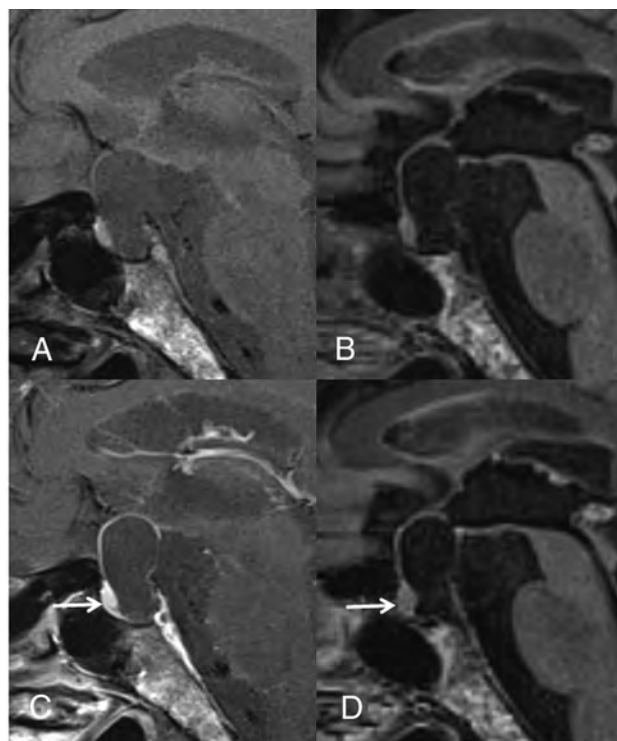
A 60-year-old man with RCC. On the postcontrast T1WI (C) compared with the precontrast T1WI (A), the cyst wall is enhanced (grade 2) and a solid enhanced area is seen (arrow). Unlike the precontrast 3D T2-FLAIR image (B), the postcontrast image (D) shows no contrast enhancement of the wall (grade 0) and the solid area (arrow). The observer judged this lesion as probably a CCP (scale 4) at the conventional MR interpretation, whereas the confidence level was changed to probably an RCC (scale 2) by the addition of 3D T2-FLAIR interpretation.
